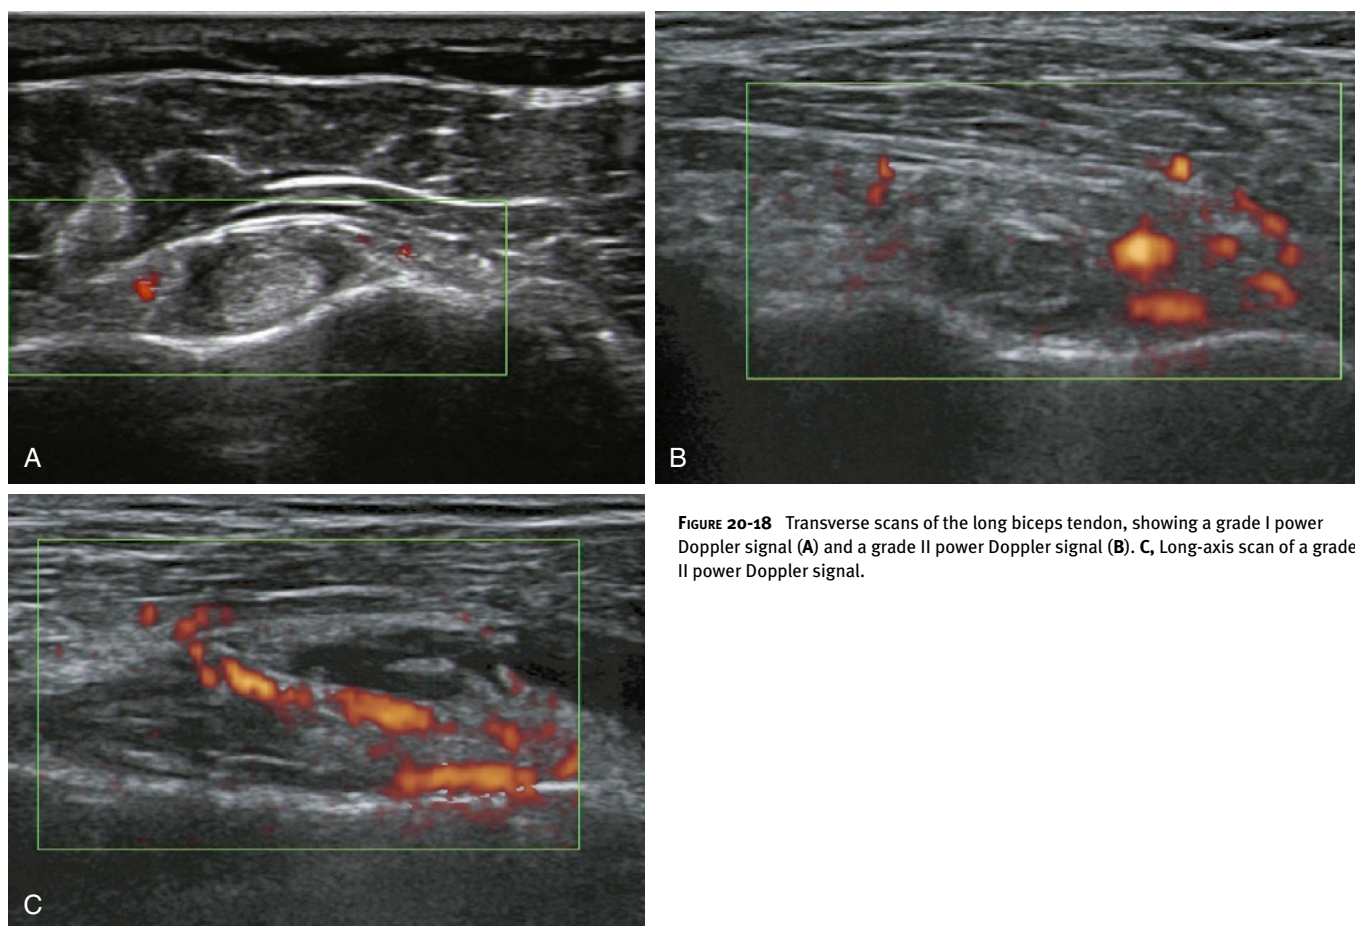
Transverse scans of the long biceps tendon, showing a grade I power Doppler signal (A) and a grade II power Doppler signal (B). C, Long-axis scan of a grade II power Doppler signal.
